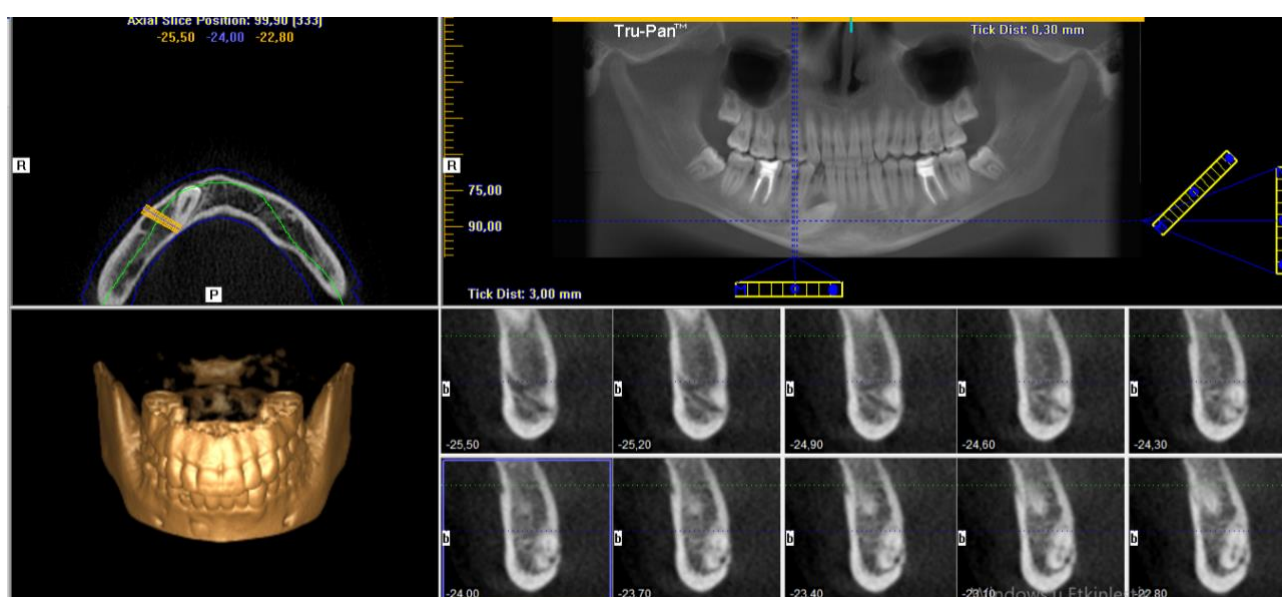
CBCT image of impacted tooth no. 43 (contact with the incisive canal; tooth root in contact with the lingual bone).
